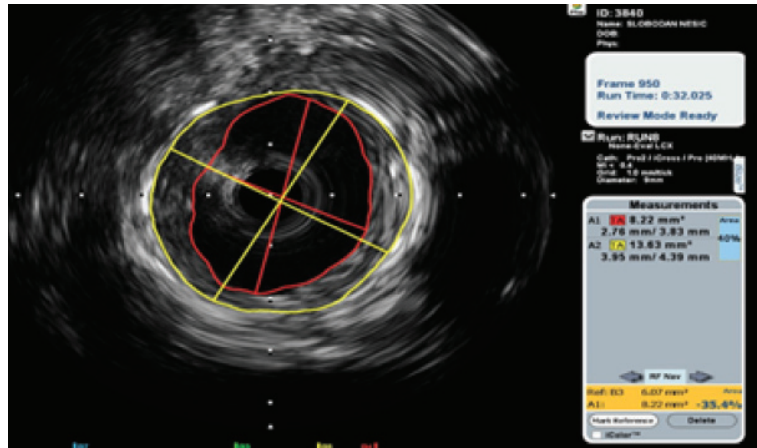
Intravascular ultrasound measurements
